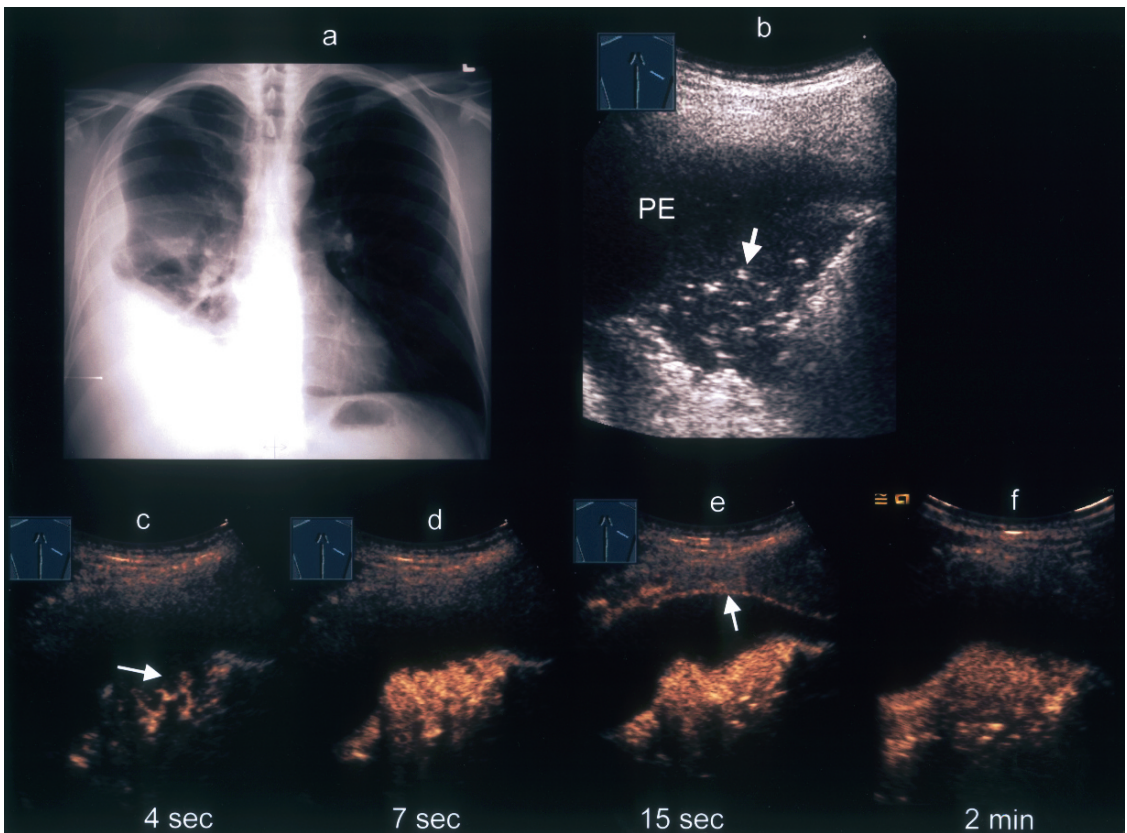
Forty-three year old male patient with dyspnoea and fever. Diagnosis of pneumonia was made. (PE = pleural effusion). A: X-ray of the chest shows right sided opacification of the lower lobe with a pleural effusion. B: B-mode sonography shows a right-sided pleural effusion with a consolidation of parts of the lung and evidence of an airbronchogram (arrow) suggesting pneumonia. C: Contrast enhanced sonography shows a short time to enhancement (4 s) of the pulmonary infiltration (arrow). This indicates a pulmonary arterial supply. D: After 7 s a homogeneous marked enhancement of the pulmonary infiltration is seen. E: After 15 s an enhancement of the intercostal artery is seen (arrow) indicating the time to systemic arterial supply. F: After 2 min the pulmonary tissue remains enhanced, whereas the thoracic wall shows a wash out phenomenon with no remaining enhancement
